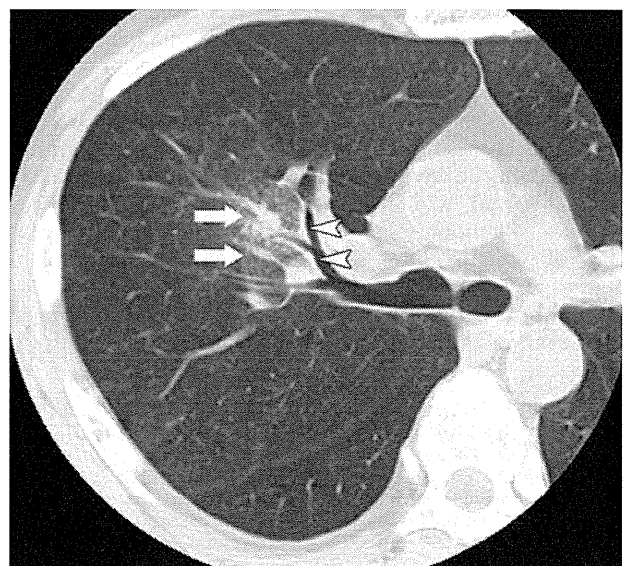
Irregular pulmonary vein dilation (case 2): chest CT scan taken during the last admission shows bronchial wall thickening (arrowhead) and irregular pulmonary vein dilation (arrows) surrounded by ground-glass opacity.
